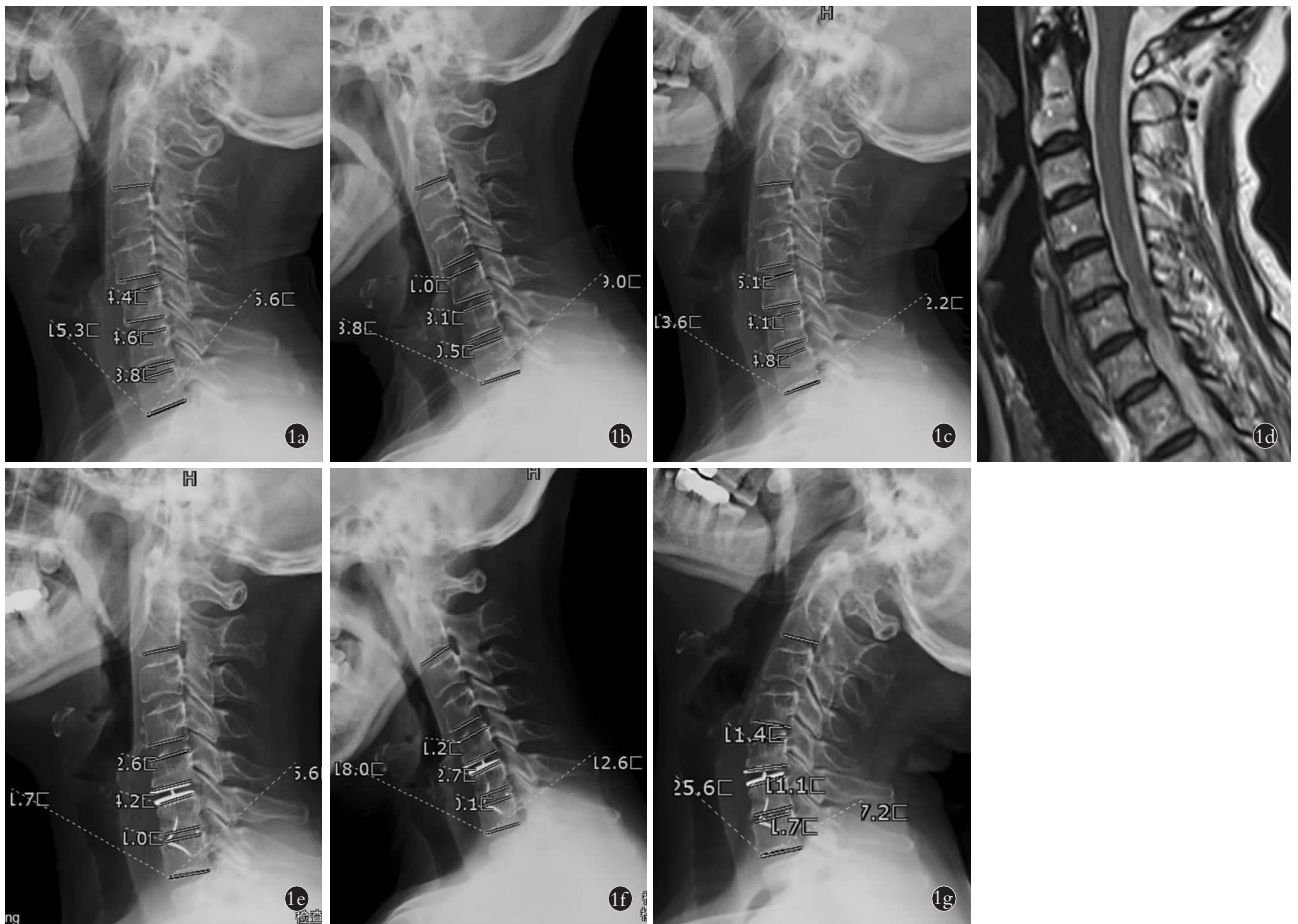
患者,女,67岁,神经根型颈椎病,颈肩疼痛伴左手桡侧三指疼痛、麻木半年,加重9d。采用 Hybrid 术治疗(C₅-C₆人工间盘置换术和 C₆-C₇颈椎前路椎间融合术) 1a,1b,1c。术前侧位 X 线片显示颈椎整体曲度和活动度减少 1d。颈椎 MRI 显示 C₅-C₇ 椎间盘突出,相应椎管狭窄 1e,1f,1g。Hybrid 术后 6 个月颈椎侧位 X 线片显示颈椎曲度和活动度明显改善,人工间盘和椎间融合器位置良好
